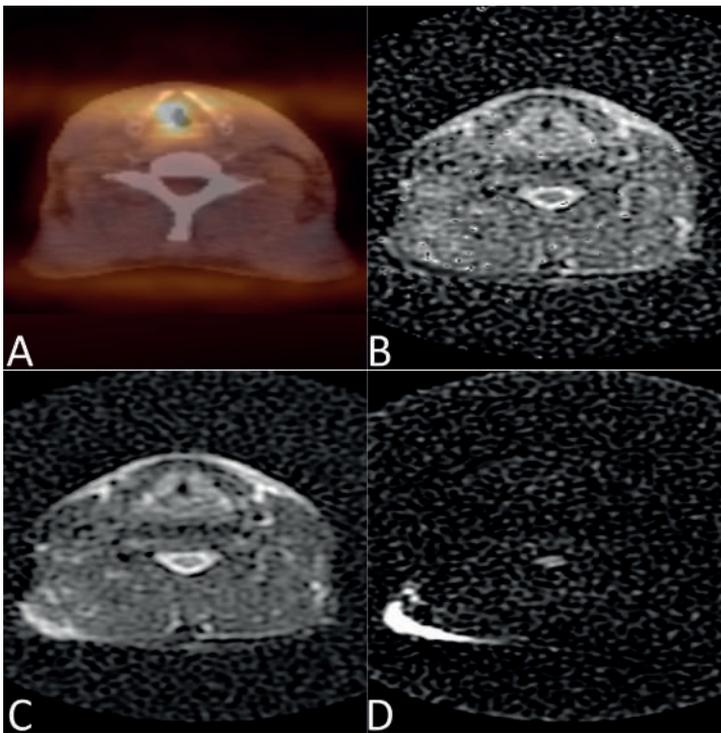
Representative images of a patient with negative DWI findings: Axial images of a 41-year old male 3 months after chemoradiotherapy for a T2N2c supraglottic laryngeal carcinoma (patient 14). On (A) PET-CT there was ^{18}F -FDG-uptake at the right supraglottic level which was substantially suspicious of malignancy with a SOM score of 3. On the PROPELLER DWI series ((B) ADC map, (C) $b=0$ s/mm^2 and (D) $b=1000$ s/mm^2) there was no suspicion of malignancy (i.e., there is neither high signal intensity on (D) $b=1000$ s/mm^2 nor low signal intensity on the (C) ADC map) with a SOM score of 1. Biopsy did not reveal malignancy and at 30 months of follow-up the patient is still in complete remission. In this patient PET-CT findings were therefore considered false-positive and DWI findings true-negative.
